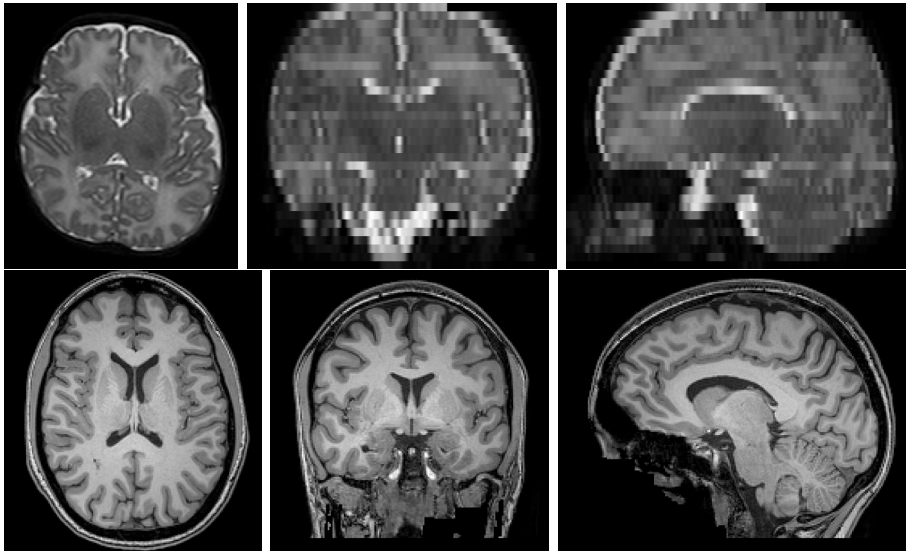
First row, a clinical T2 weighted MRI from the MAIA dataset (subject S00059). It presents a strong anisotropic resolution across the coronal and sagittal planes ( $0.45 \times 0.45 \times 3$  mm). Second row, an adult T1 weighted MRI from the dataset NKI-RSS-22 (subject 1). It presents an isotropic resolution ( $1 \times 1 \times 1$  mm).
